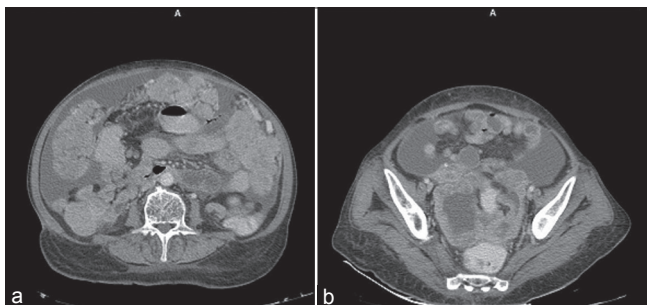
(a) Contrast-enhanced CT scan shows omental caking and ascites (b) Contrast-enhanced CT scan shows ascites and pelvic peritoneal thickening
